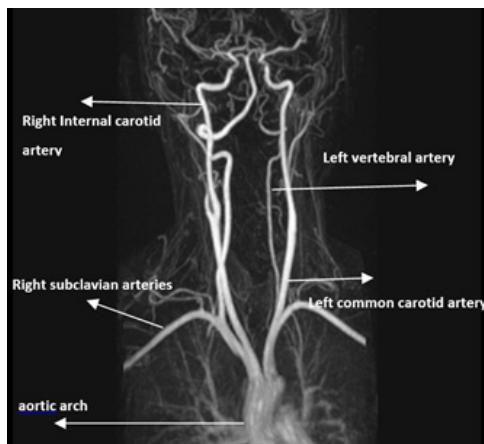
MIP. Adapted from (private MRI clinic).
